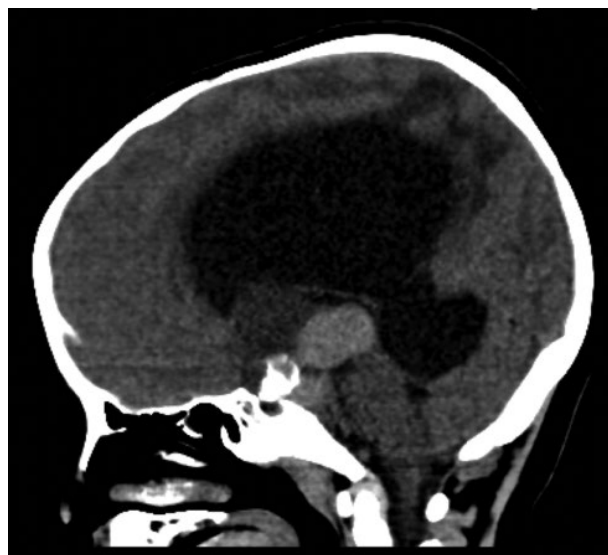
Sagittal gadolinium-enhanced T1-weighted MR image showing a 5-year-old girl with a large craniopharyngioma filling the suprasellar cistern and elevating and distorting the third ventricle. A heterogeneous mass is centered in the suprasellar cistern, most compatible with craniopharyngioma. There is obstruction at the third ventricle and cerebral aqueduct with resulting severe hydrocephalus and generalized mass effect/increased intracranial pressure.
